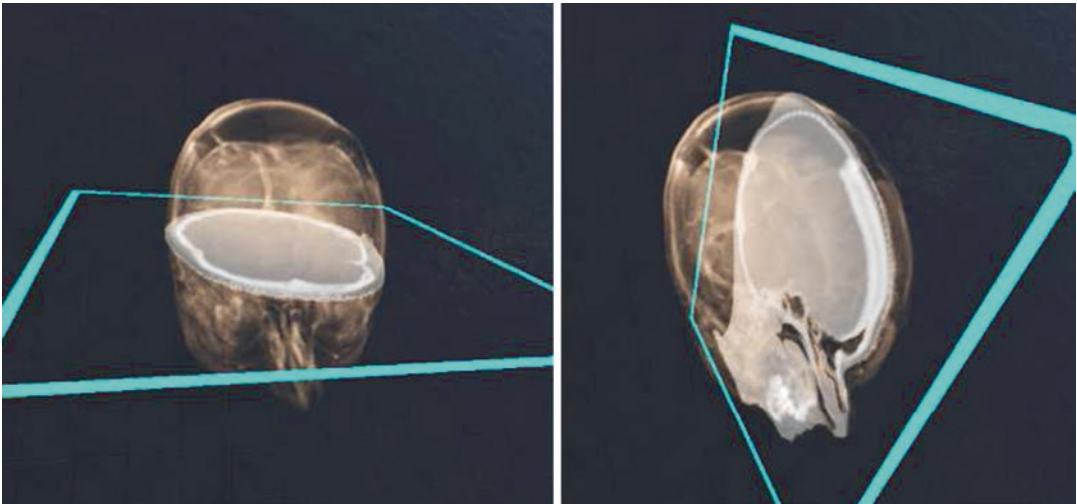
Example of interacting with volume rendering image sets (fused MRI and CT) using a handheld virtual plane to navigate through the image set in any arbitrary orientation
